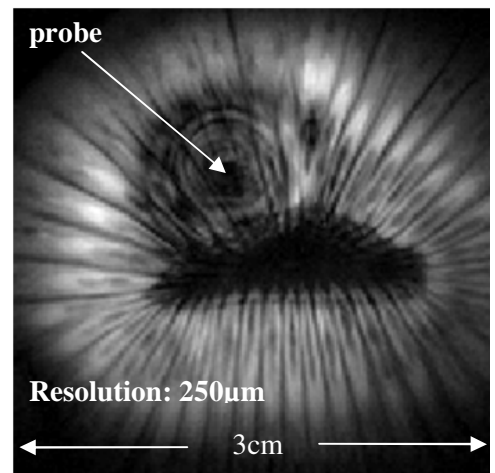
Gradient echo MRI of kiwifruit. Slice localization arises entirely from probe sensitivity. TR/TE = 3000/12 ms. FA 80°.
